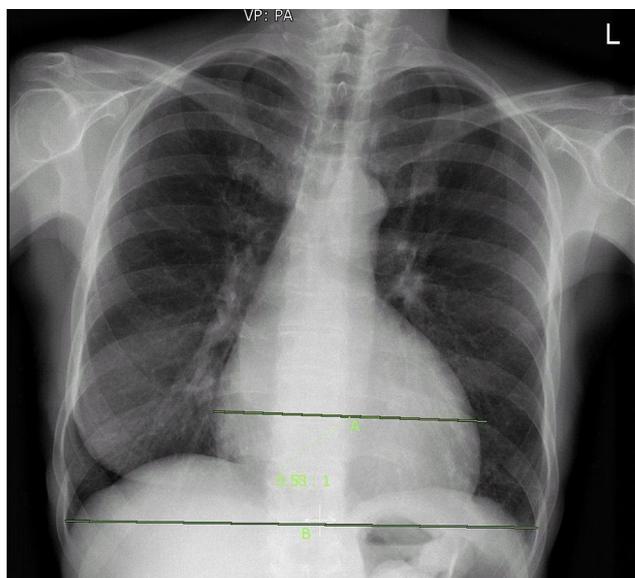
Chest X-ray at investigation following first cardiac symptoms with visible Kerley B lines.
